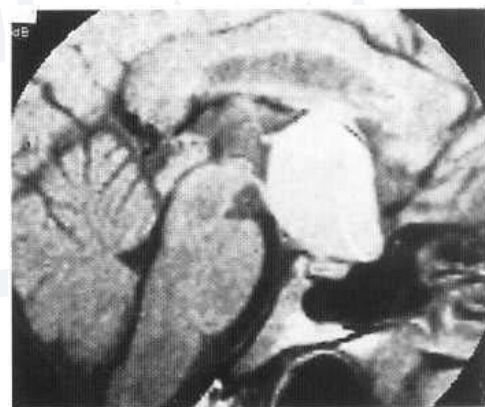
Craniopharyngioma. Sagittal midline MRI (T_2 -weighted) shows high-signal suprasellar mass due to cystic tumour. (Courtesy of Dr Gordon Thomson and Bristol MRI Centre.)
